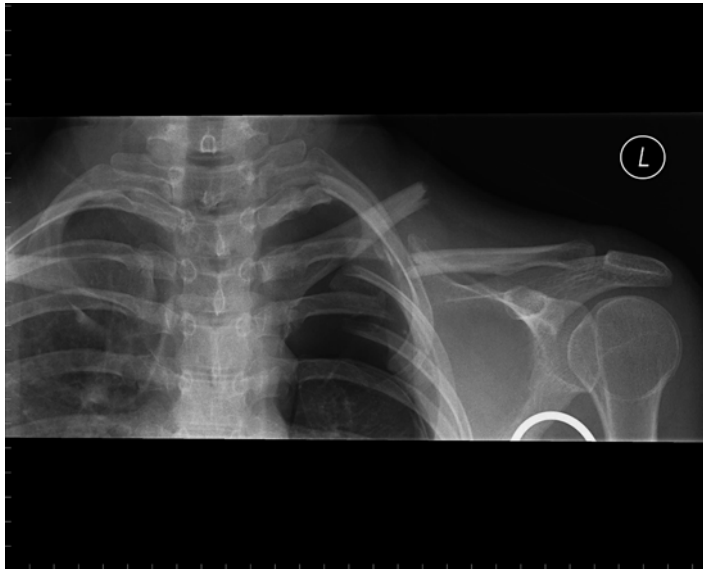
Radiograph of a young trauma patient with a displaced mid-shaft fracture of the clavicle and multiple displaced ipsilateral upper rib fractures. An associated pneumothorax emphasizes the severity of the injury: this pattern represents a severe destabilization of the entire
